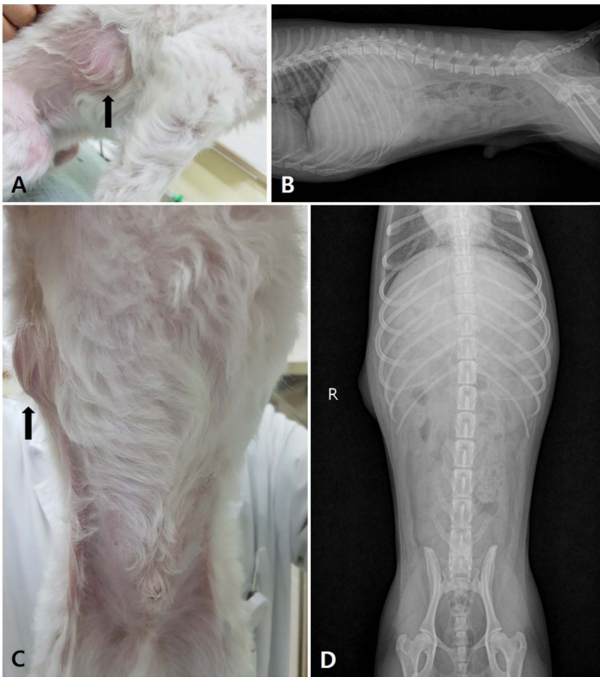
Clinical appearances and radiograph images. Hard subcutaneous mass on left flank area (A) and (C) and lateral (B) and ventral (D) views on radiography. Black arrows show subcutaneous mass.
